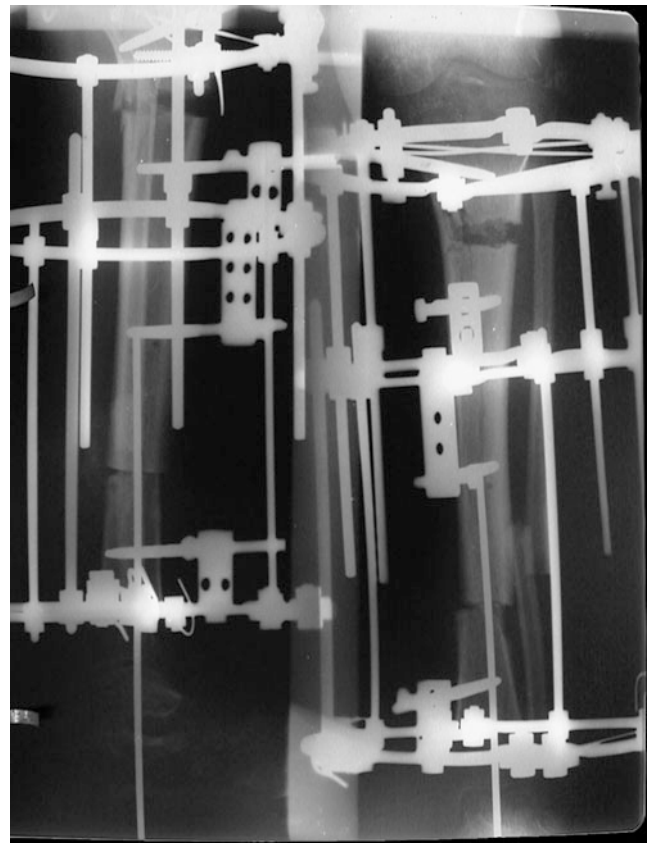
Postoperative radiographs show the fibular osteotomy and overlap of fibular bone ends to allow leg shortening. A temporarily inserted Kirschner wire guides the acute shortening and prevents deflection of bone ends due to laxity of soft tissues. Proximal tibial osteotomy is performed for re-lengthening of the tibia
